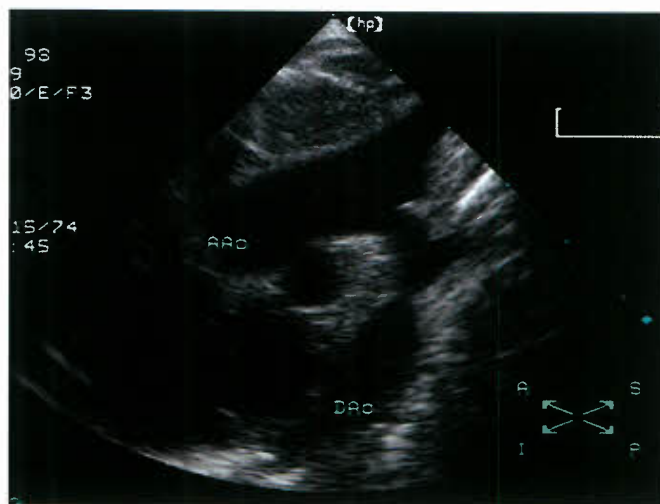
Two-dimensional echocardiogram obtained in the suprasternal long-axis view demonstrating a discrete coarctation of the aorta. Aao, ascending aorta; Dao, descending aorta.
